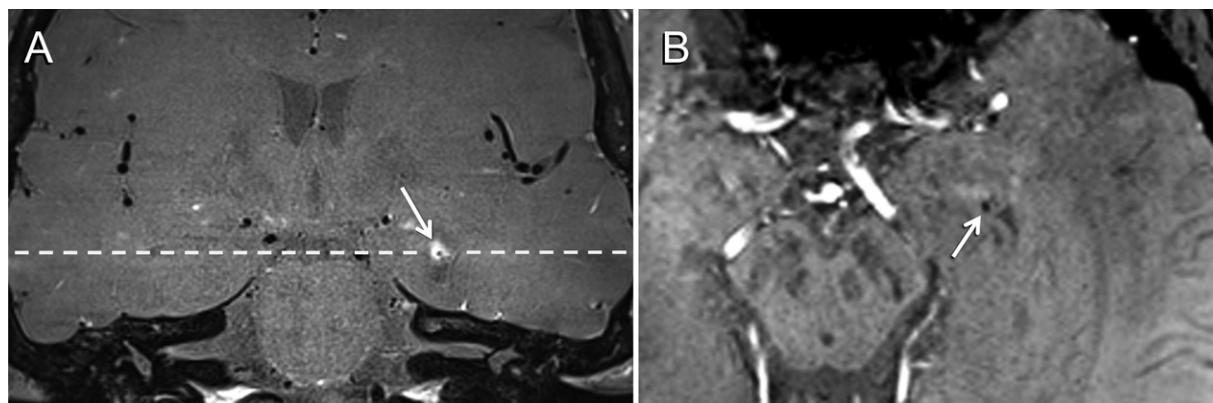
Microhemorrhage with surrounding enhancement mimicking perivascular enhancement with vasculitis in a 34-year-old man with multiple small strokes. (A) Coronal postcontrast vessel wall (VW) MRI scan shows prominent enhancement surrounding a tiny hypointense focus in the left temporal lobe (arrow). (B) This corresponds to a punctate hypointense focus on the susceptibility-weighted image, suggesting a microhemorrhage (arrow). Enhancement and hypointensity did not show a linear configuration on the VW MRI scan or susceptibility-weighted image, respectively, as would have been expected if it had been a flow-suppressed vessel with surrounding inflammation.
